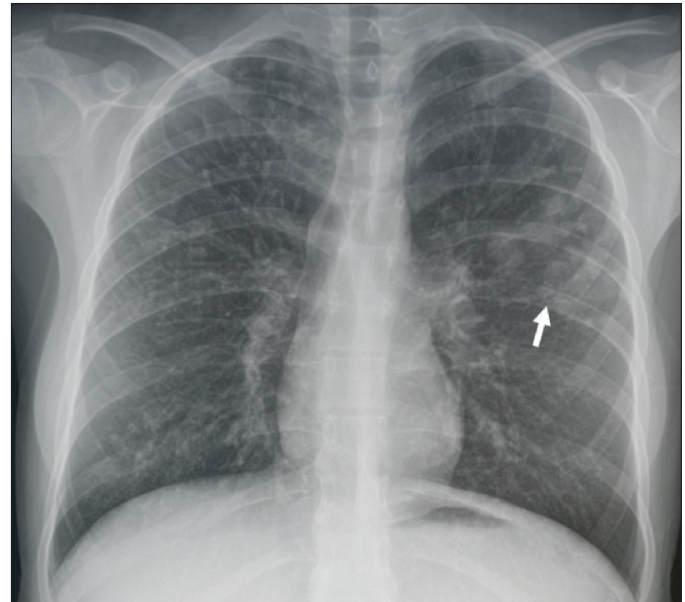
Posteroanterior chest radiograph. Radiopaque area in the upper-middle zone of the left lung (white arrow) and peribronchial wall thickening and accompanying bronchiectasis are observed in both lungs.
